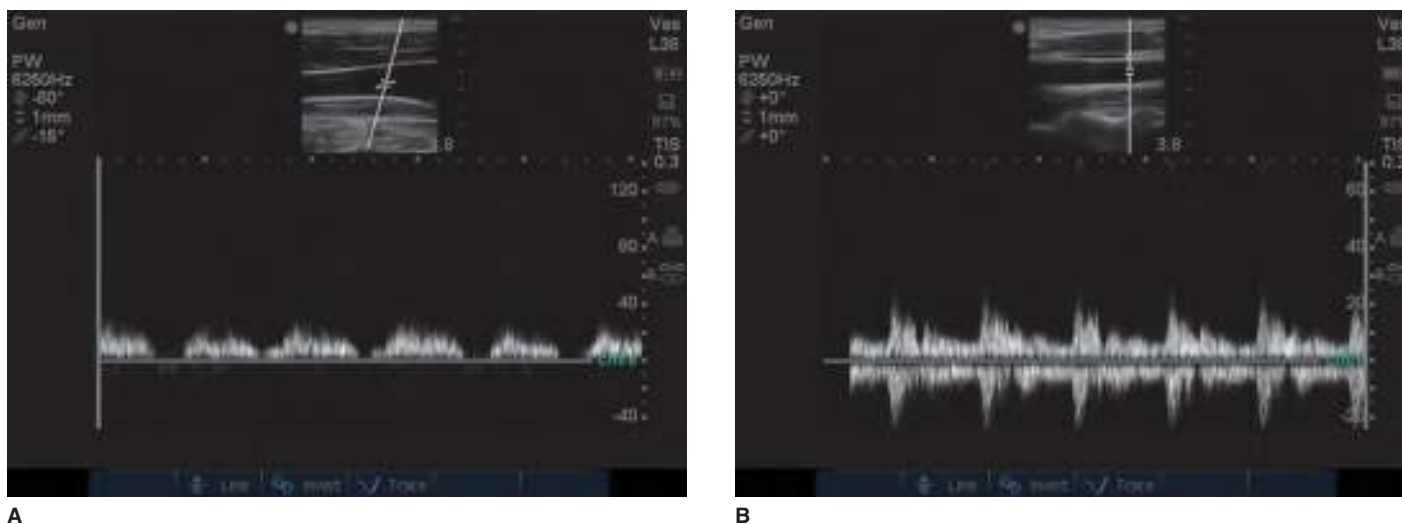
Long axis US images of spectral Doppler waveforms. A. The internal jugular vein. B. The carotid artery.
